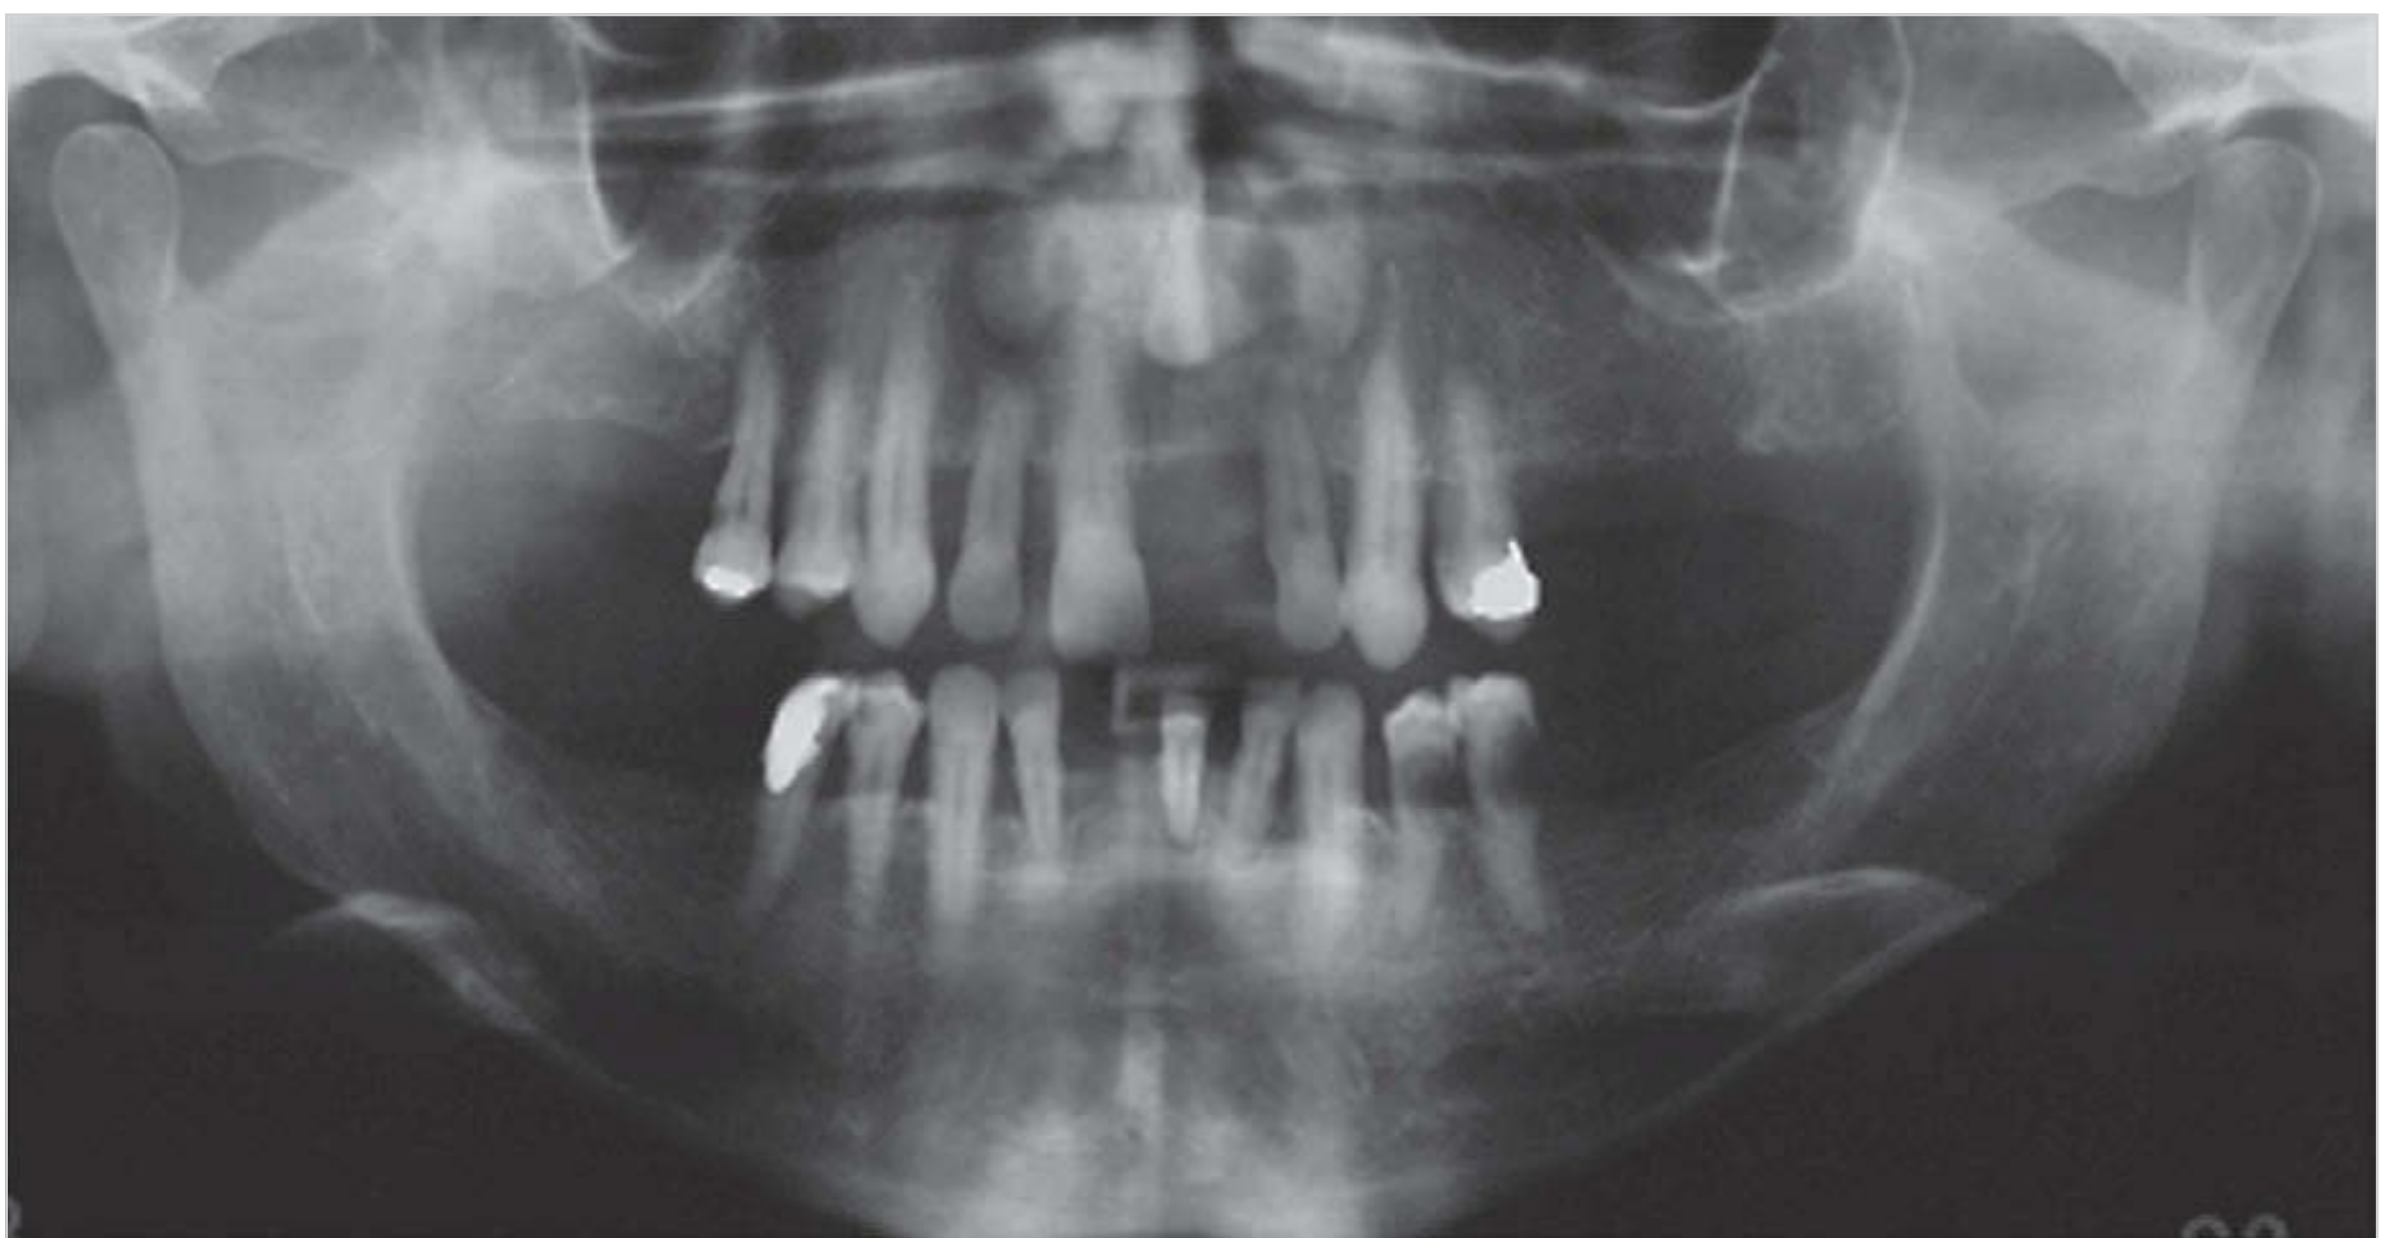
Soft-tissue shadow of the nose in the upper anterior region of a panoramic radiograph.
